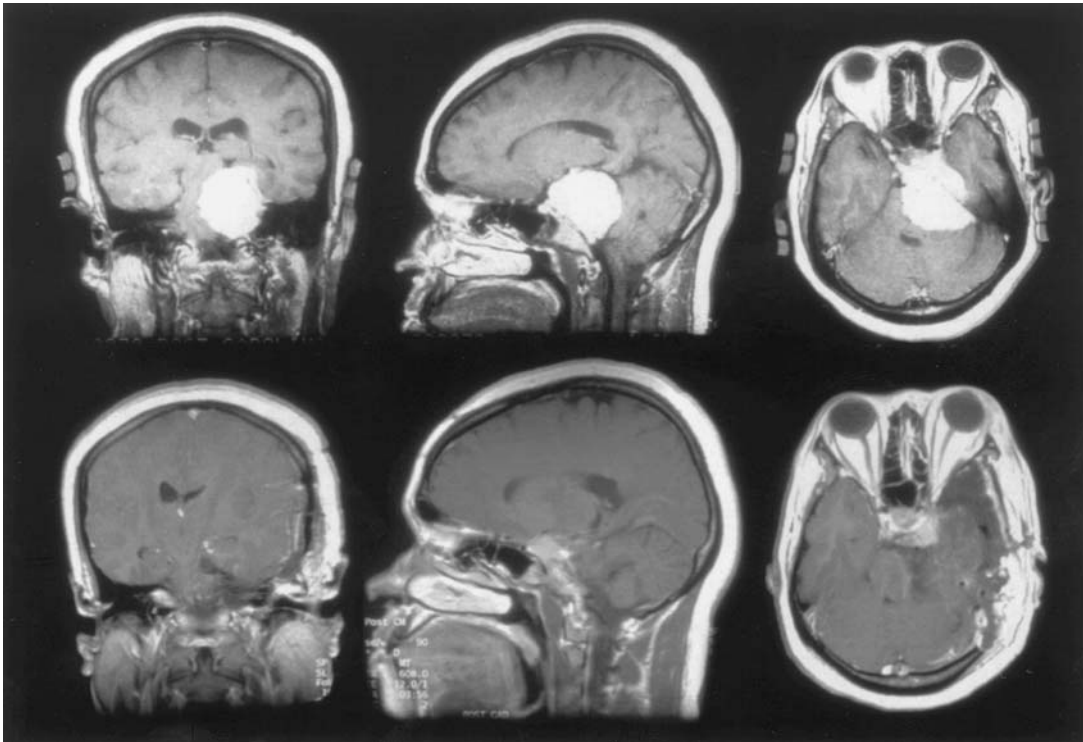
Coronal, sagittal and axial gadolinium-enhanced T1-weighted MR images of a 36-year-old female patient who presented with unsteady gait and cerebellar ataxia (upper left, upper middle and upper right). This large tumor, involving both the petroclival and cavernous sinus regions, was resected in two-staged operations. A small tumor nodule adherent on the intracavernous ICA was left (lower left, lower middle and lower right). Post-operatively, she developed hearing loss and mild hypesthesia in the left V2 and V3 distributions, but her extraocular motility was normal with resolution of her presenting unsteadiness and ataxia. This residual tumor is being observed closely, with plans of gamma knife radiosurgical intervention in the event that the tumor progresses in the future.
